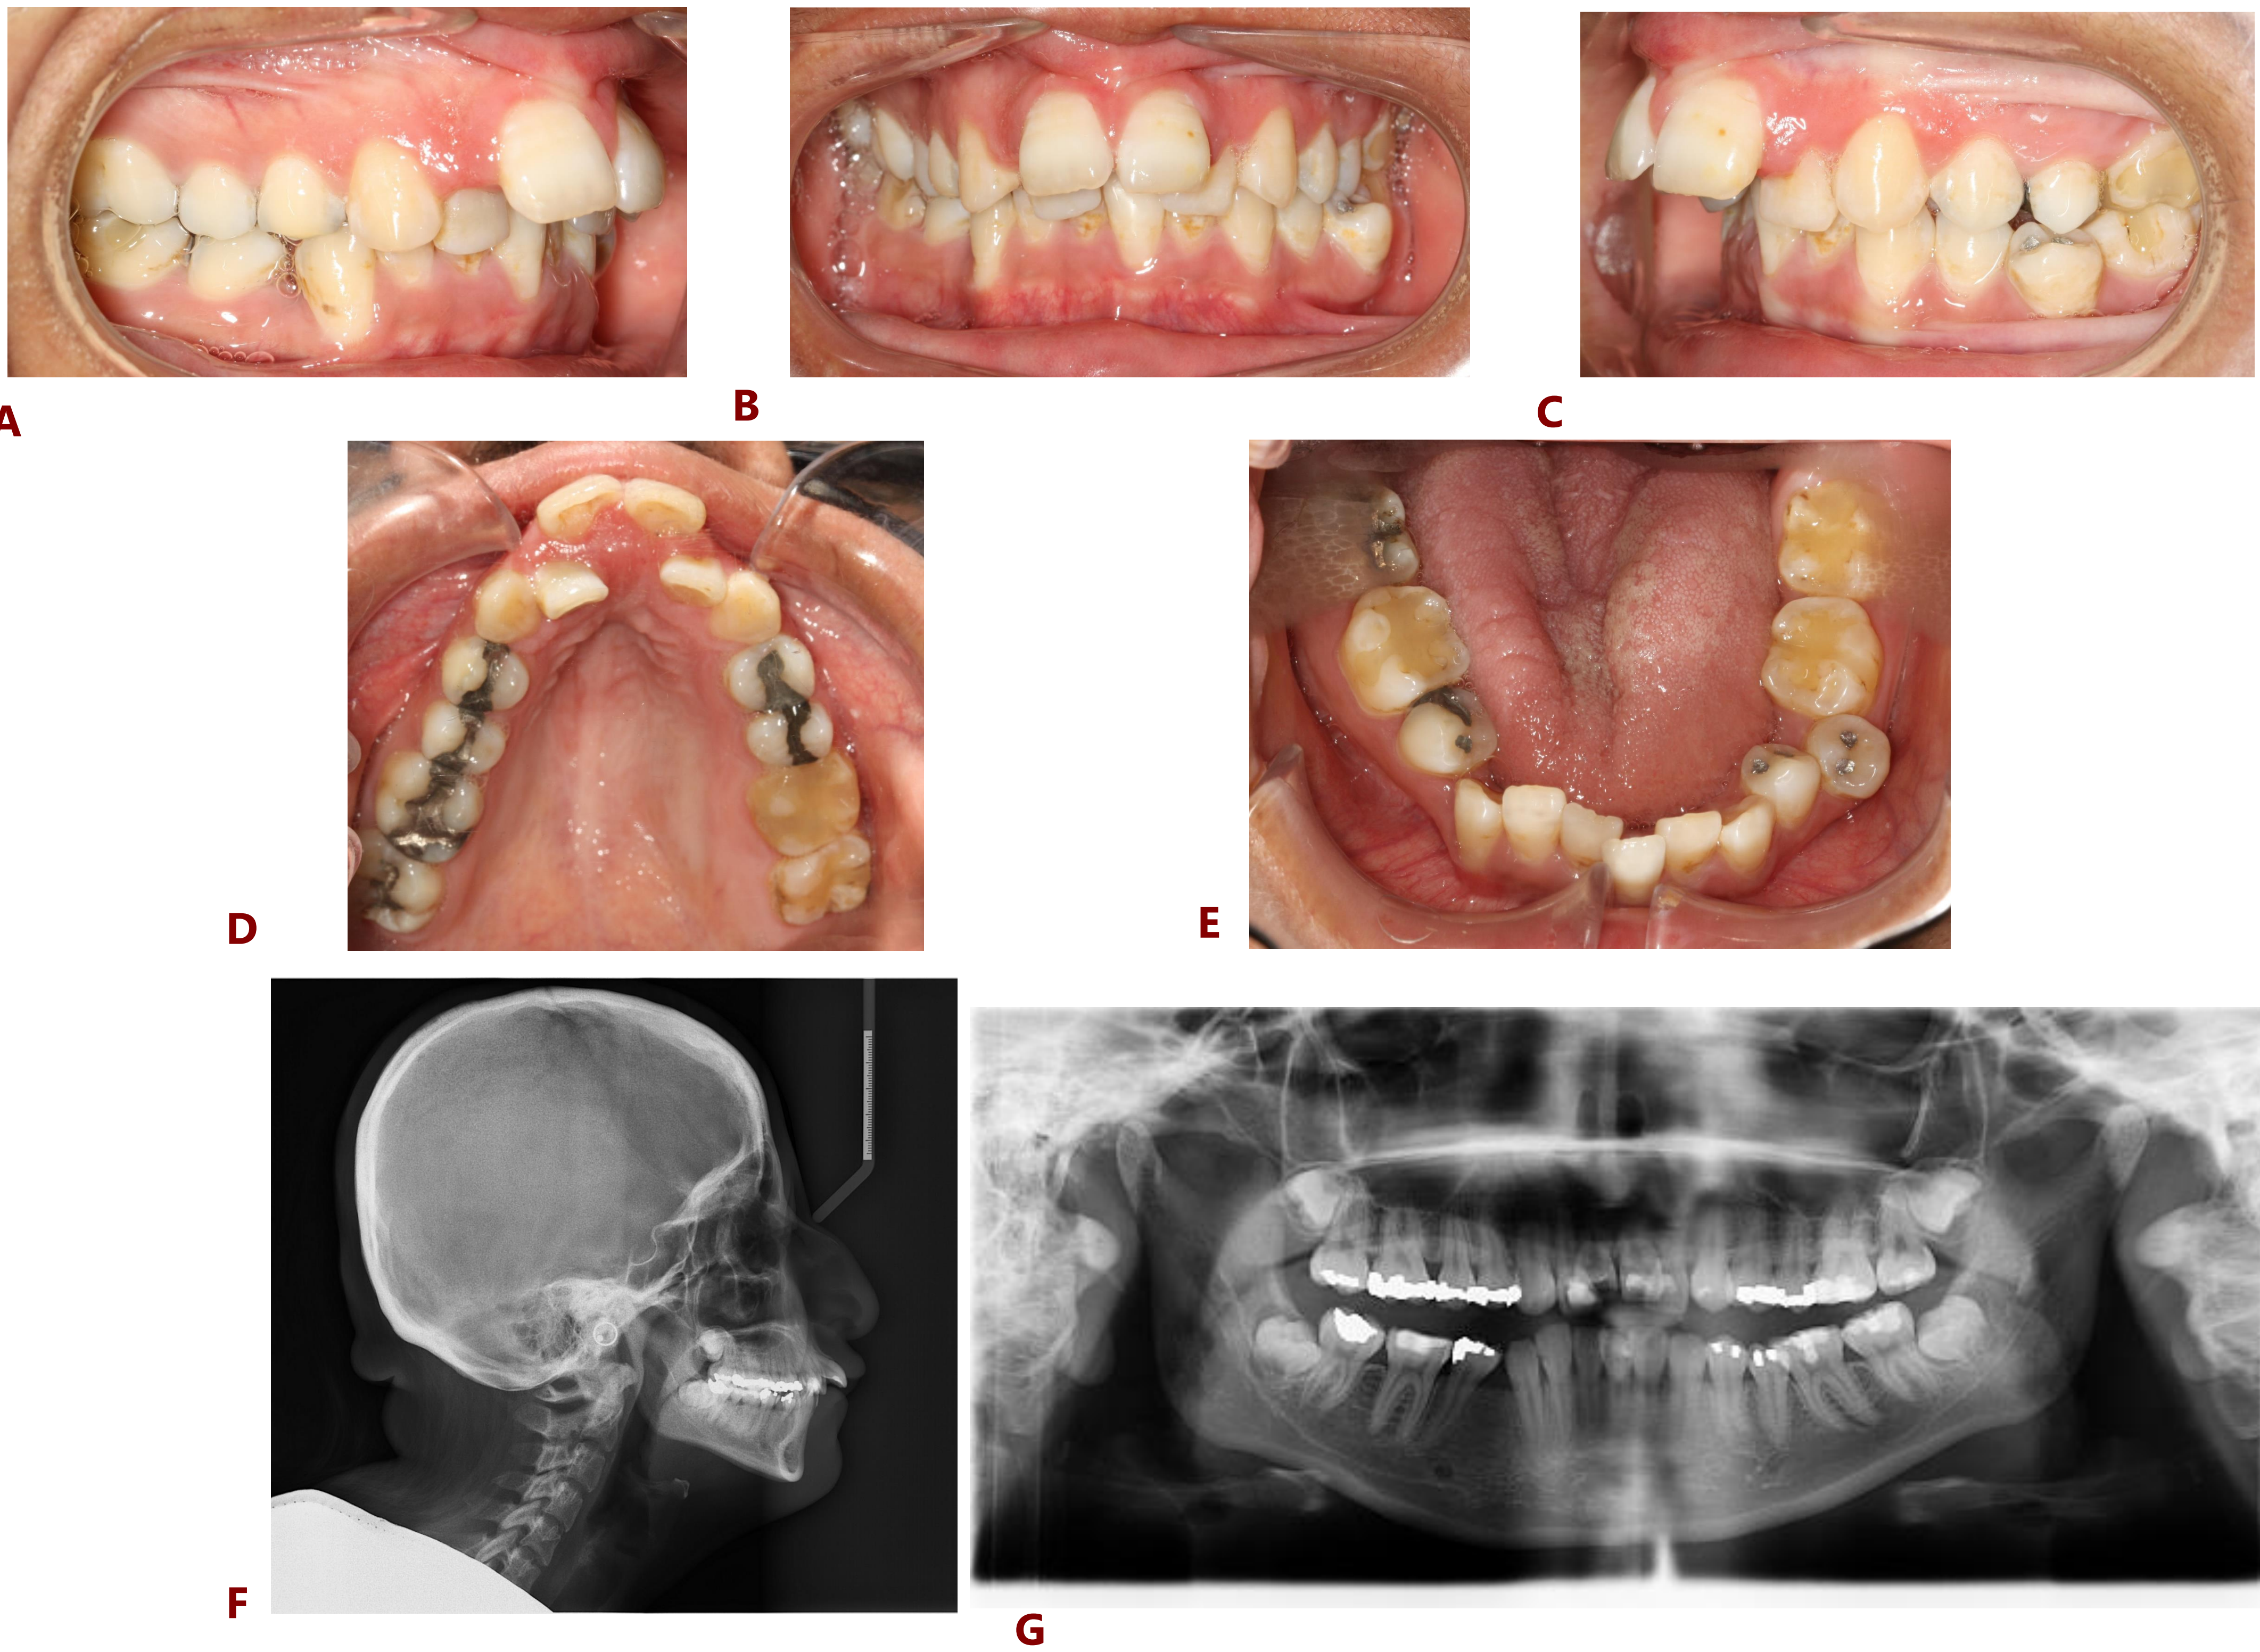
Pre-treatment records A) Right Buccal B) Intraoral Frontal C) Left Buccal D) Maxillary Occlusal E) Mandibular Occlusal F) Lateral Cephalometric Radiograph G) Panoramic Radiograph
